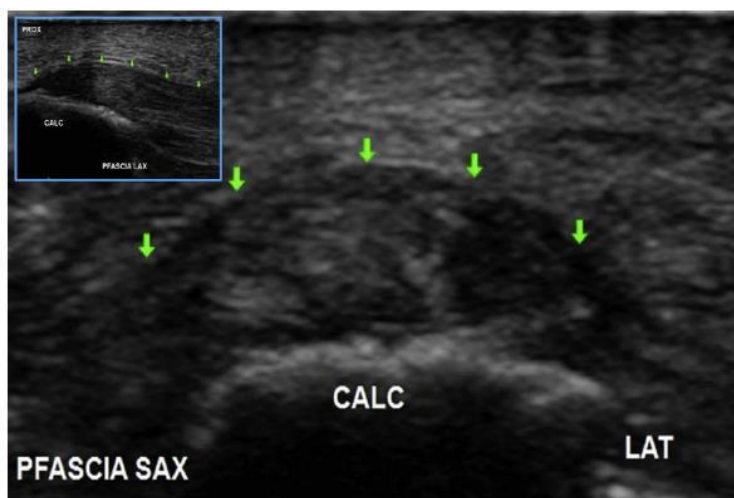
Correlative short axis ultrasound view of a thickened, heterogenous, hypoechoic plantar fascia (PFASCIA) typical of chronic plantar fasciosis. *Top*, Plantar/superficial; *bottom*, dorsal/deep; *left*, medial; *right*, lateral (LAT). Arrows identify superficial portion of plantar fascia. Inset shows correlative long axis (LAX) view, proximal to the left. CALC, calcaneus.
